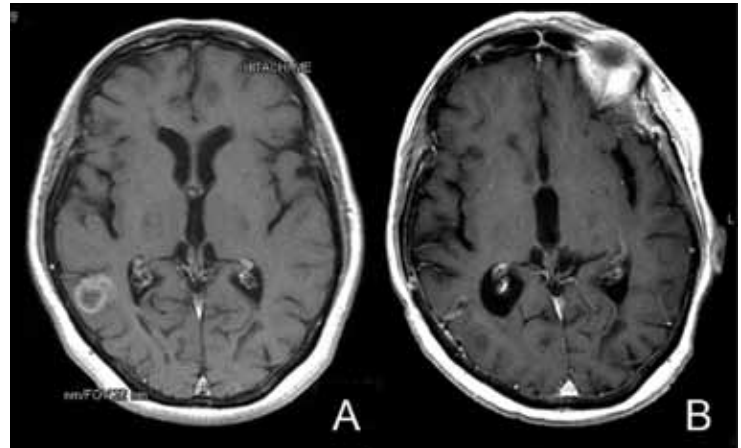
Right parietal brain metastasis from breast cancer. Magnetic resonance imaging of the brain with contrast (A) at diagnosis and (B) after surgical resection.
